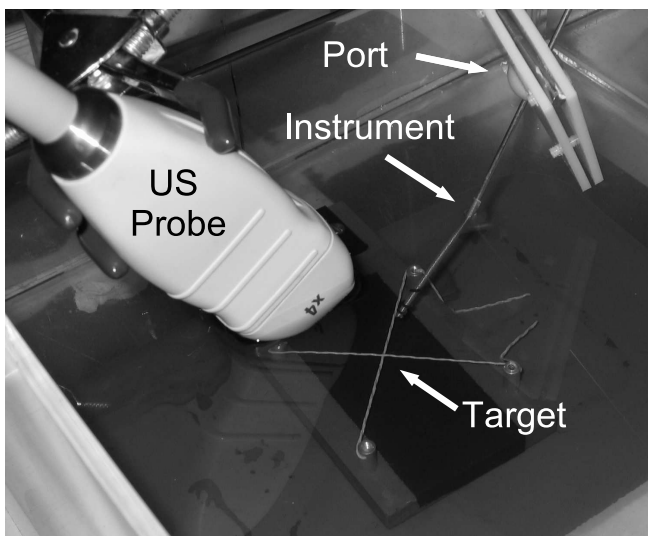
Image of the test setup. The 3D ultrasound probe is shown imaging the target and the surgical instrument in a water tank. The surgical instrument is attached to a small robot and inserted through a port.
